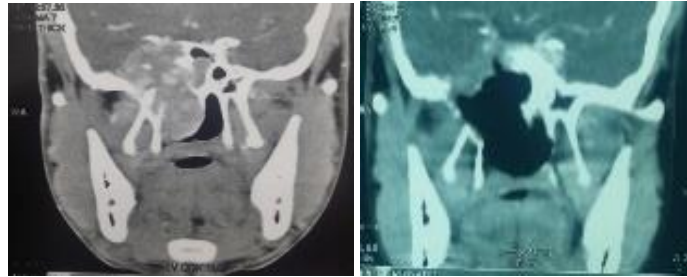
CT image showing (a) JNA with cavernous sinus involvement (stage IV b). (b) Post-operative imaging with no recurrence
